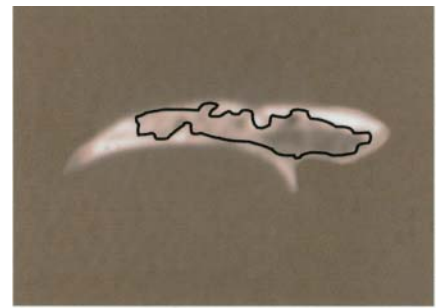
Computed tomography section in the intended plane of the implant placement with the region of interest bordered by a black line.
